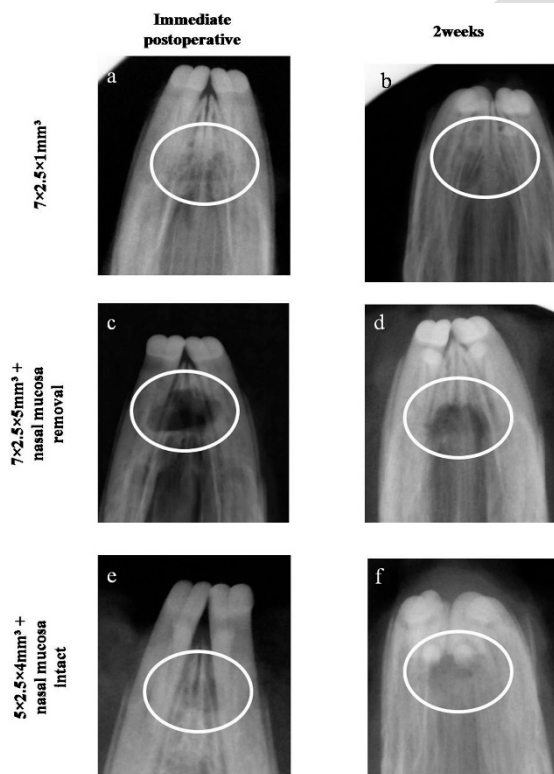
Showing representative radiographic images with frames representing defect areas of different defect dimensions used for optimization of the created model. (a, c & e) Images represent immediate surgically created defects; whereas (b, d & f) represent 2 weeks postoperative interval defects. (a & b) Images show defects of 7×2.5×1 mm³ dimensions with injury in the roots of main and peg incisors teeth root and almost complete closure of the defect restoring the normal palate contour at 2 weeks. (c & d) Images demonstrate defects of 7×2.5×5 mm³ dimensions showing extensive injuries in peg tooth roots and bone overlying main incisor. (e & f) Images show the optimized created defects of 5×2.5×4
